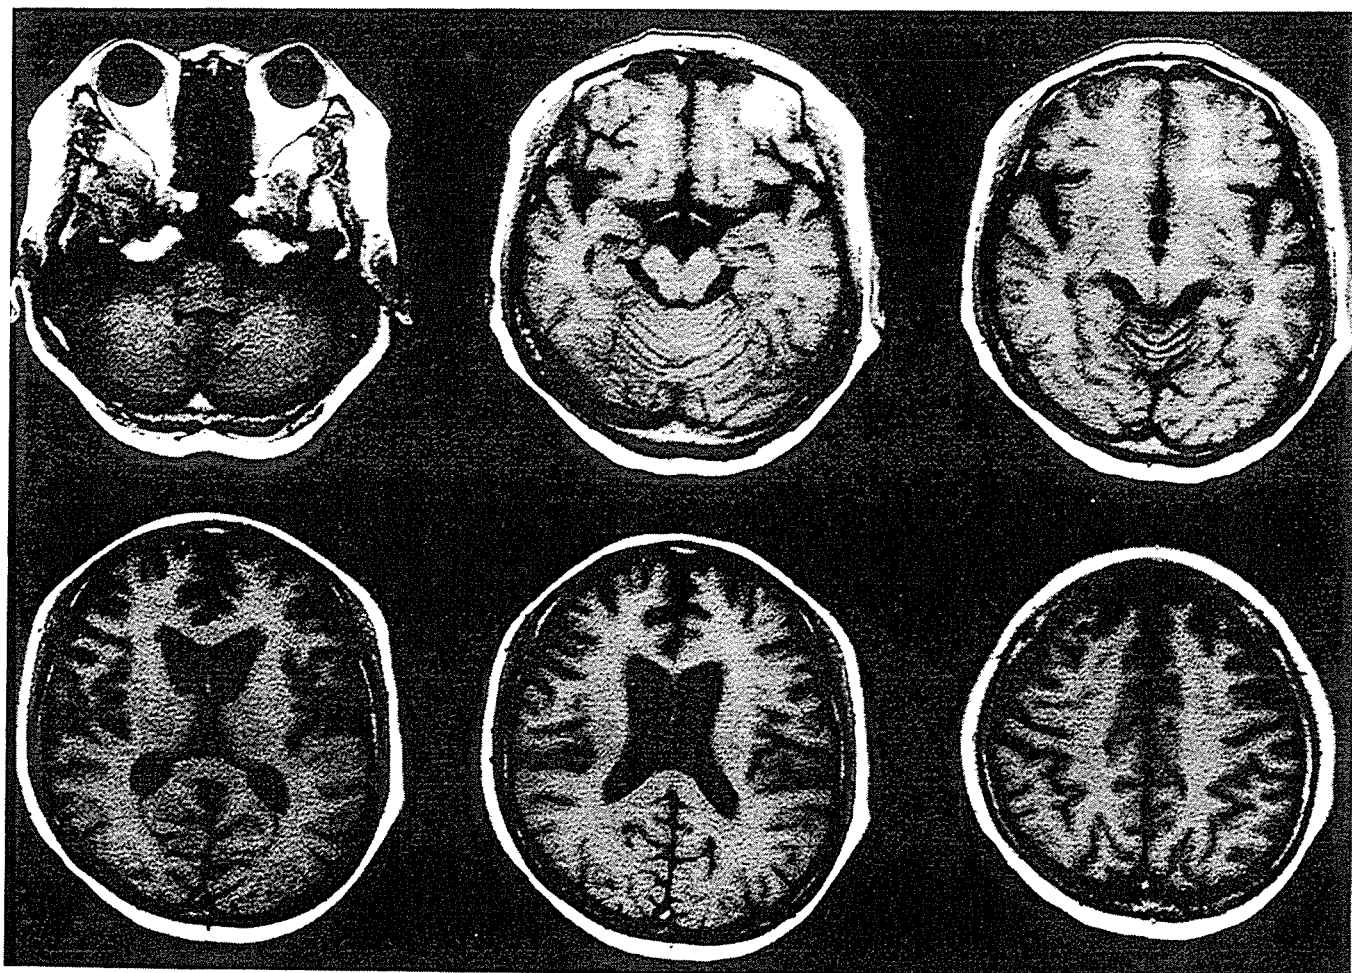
MRI performed on the first admission. The anterior horns of the bilateral lateral ventricles are enlarged, suggesting atrophy of the caudate head.
